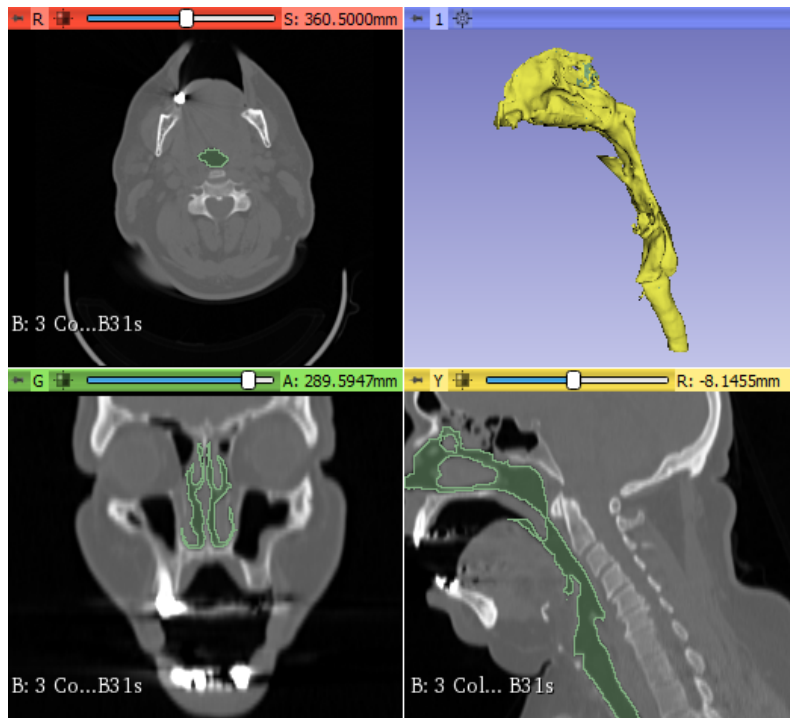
Screenshot from the viewing window in 3D slicer, after the segmentation procedure is completed for patient 6. The green areas in the figure are the segmented airways. The top left window shows the CT image in a top-down view, while the lower-left and lower-right windows are from the front and side, respectively. The top-right window shows the 3D model resulting from the extraction procedure.
